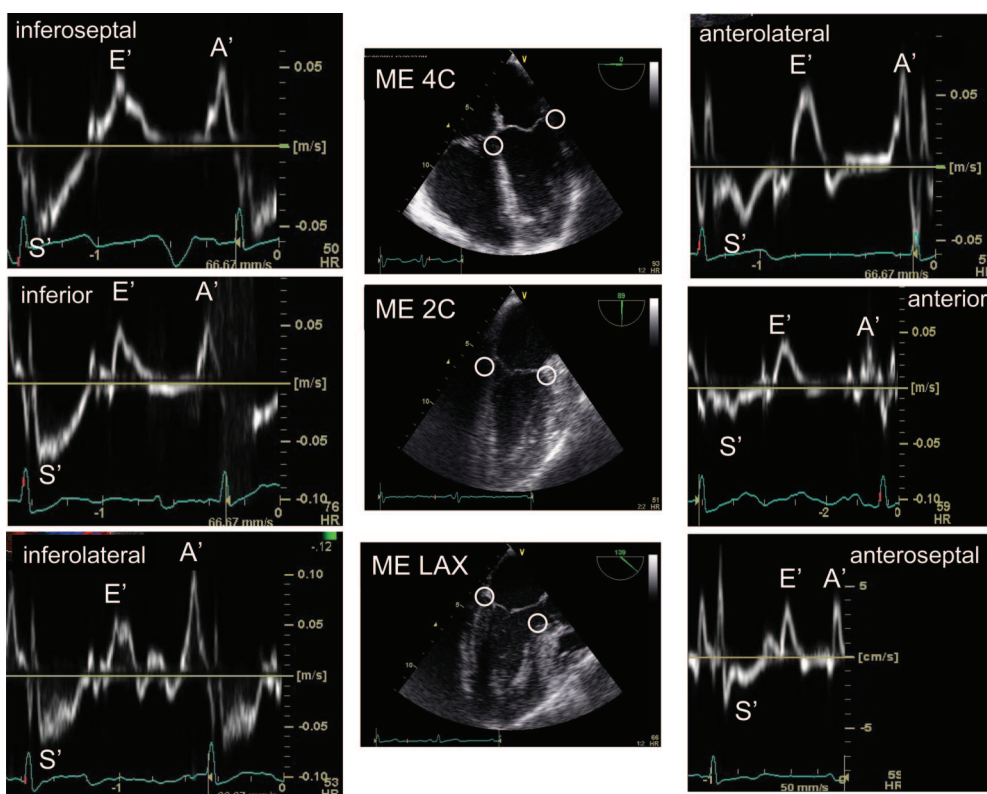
Longitudinal myocardial velocities (spectral Doppler tissue imaging) recorded from sample volumes (white circles) positioned lateral to the mitral annulus, in the standard SCA/ASE tomographic views of the left ventricle: mid-esophageal (ME) four chamber (ME 4C), two chamber (ME 2C), and long axis (ME LAX). Notice the relative blunting of S' velocities in anterior and anteroseptal myocardial segments, where Doppler angle between the direction of ultrasound and the plane of motion is usually $>20^\circ$. S' = systolic; E' = early diastolic; A' = late diastolic myocardial velocities.
